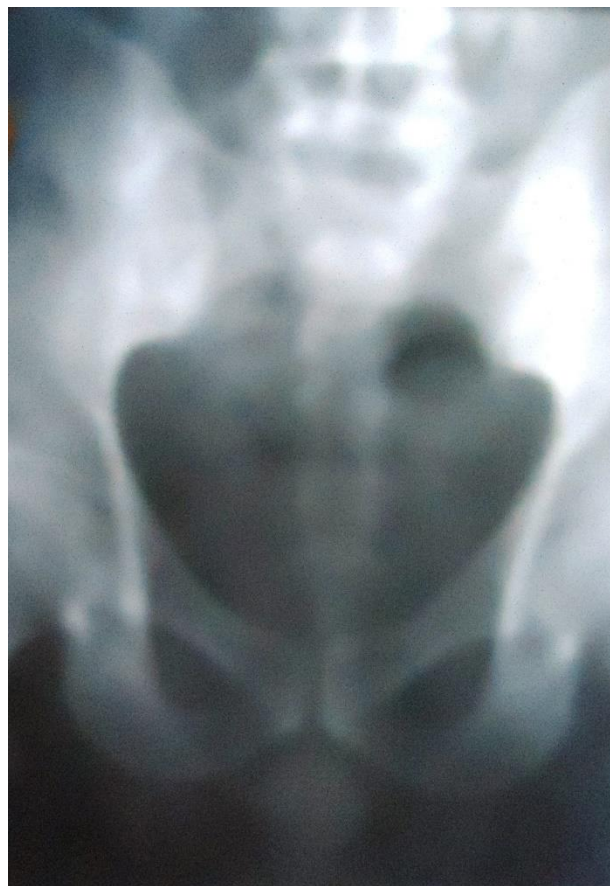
Abdominal X-ray of the next day, showing the absence of the radiopaque crown which was spontaneously passed through the stool
